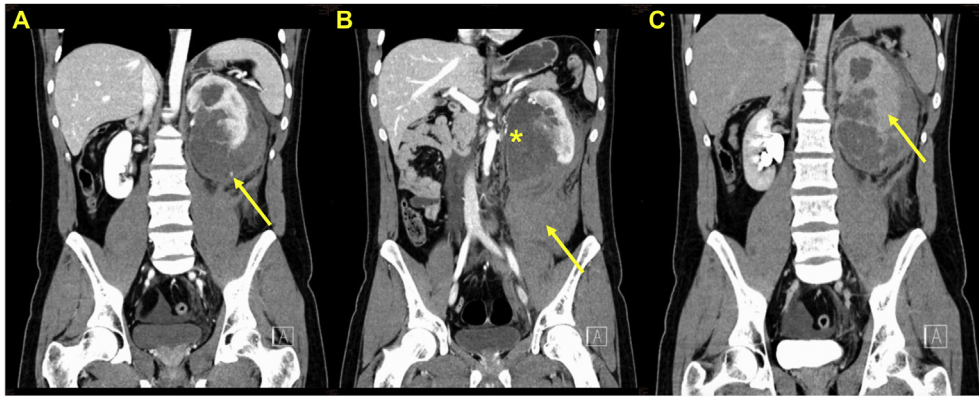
Abdominal computed tomography (CT) scan showing active extravasation of a segmental renal artery (A, arrow), with a 17 × 8 × 4 cm retroperitoneal hematoma (B, arrow), and also a hematoma (retrospectively tumor) near the renal hilum (B, asterisk). Nephrographic phase revealed no urinary extravasation of the affected kidney, but with poor function (C, arrow).
